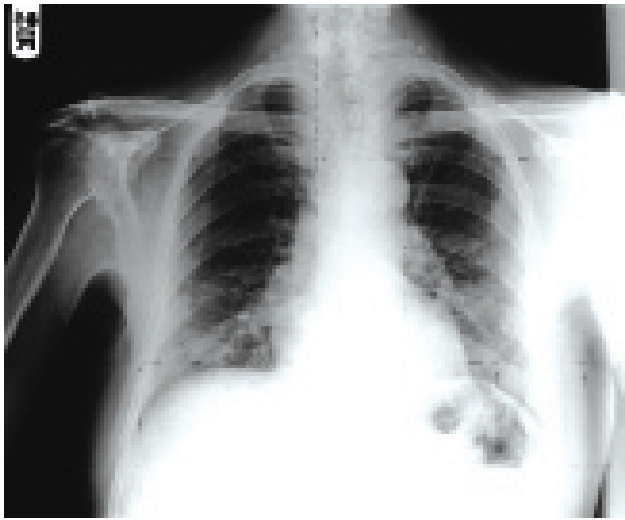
The new chest radiography with bibasal fibrotic changes and increased interstitial pattern
